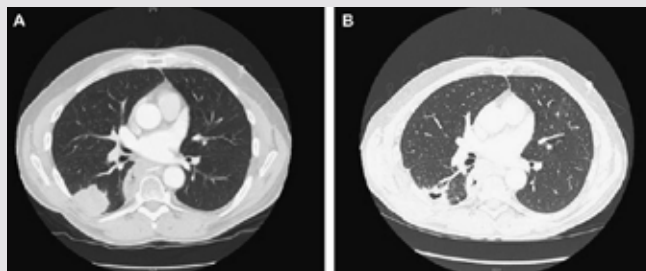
Representative CT scans showing a tumor before (A) and after (B) radiofrequency ablation.
